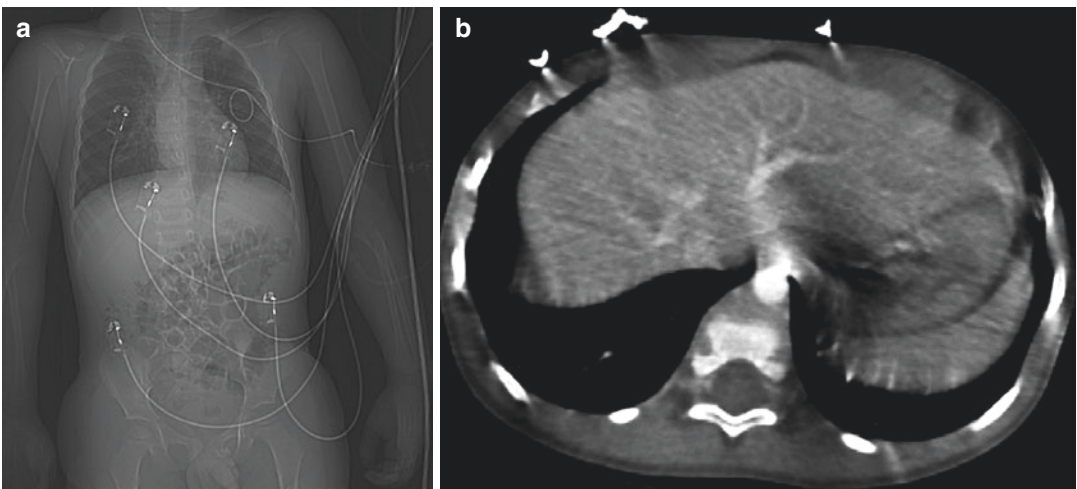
Four year old girl. (a) Scout view: incorrect placement on CT table. (b) CT with contrast: liver and abdominal wall artefacts due to the multiple metallic cables on the field of view
